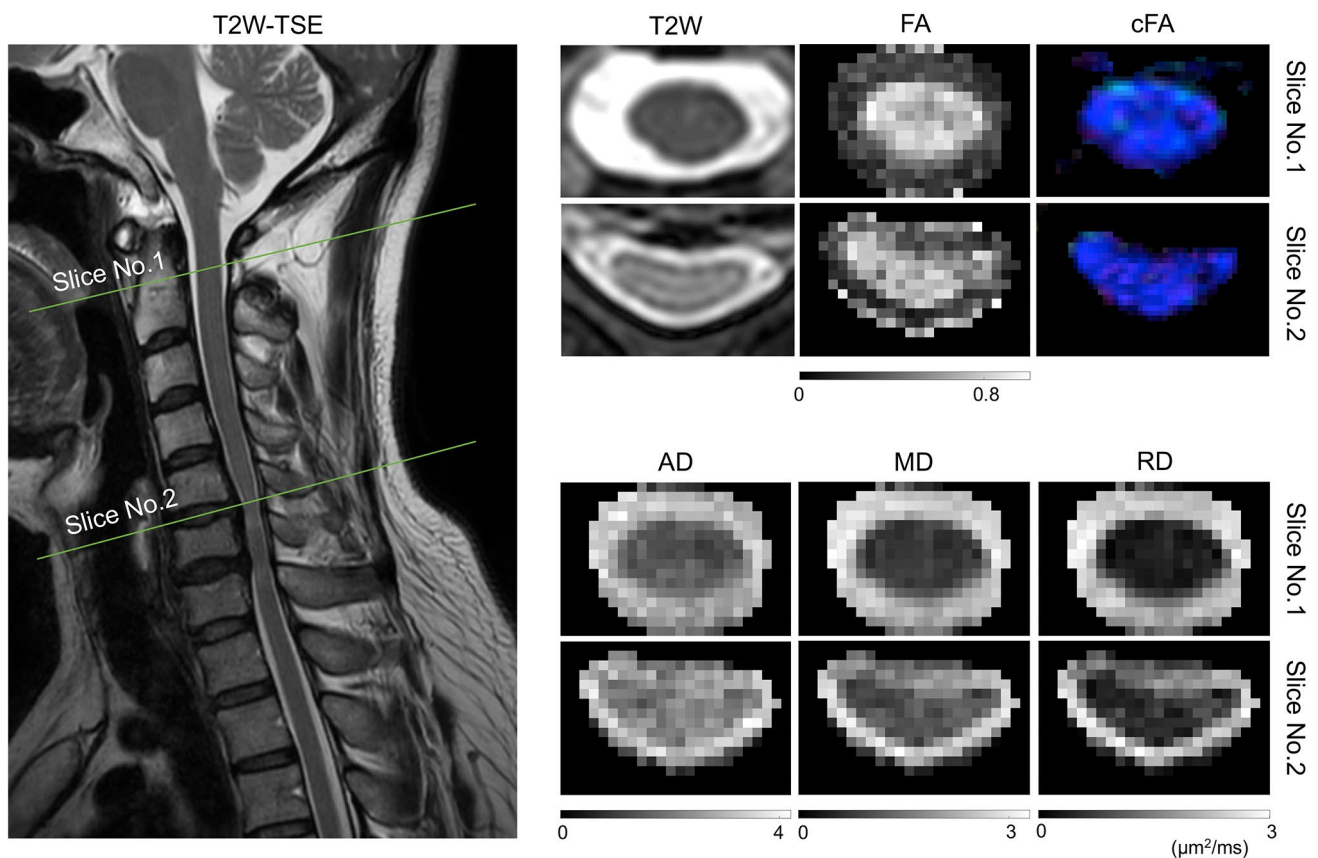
The T2W anatomical MR image along with calculated DTI metrics and color encoded FA maps (cFA) for a non-compressed slice (Slice No. 1) and a compressed slice (Slice No. 2)
